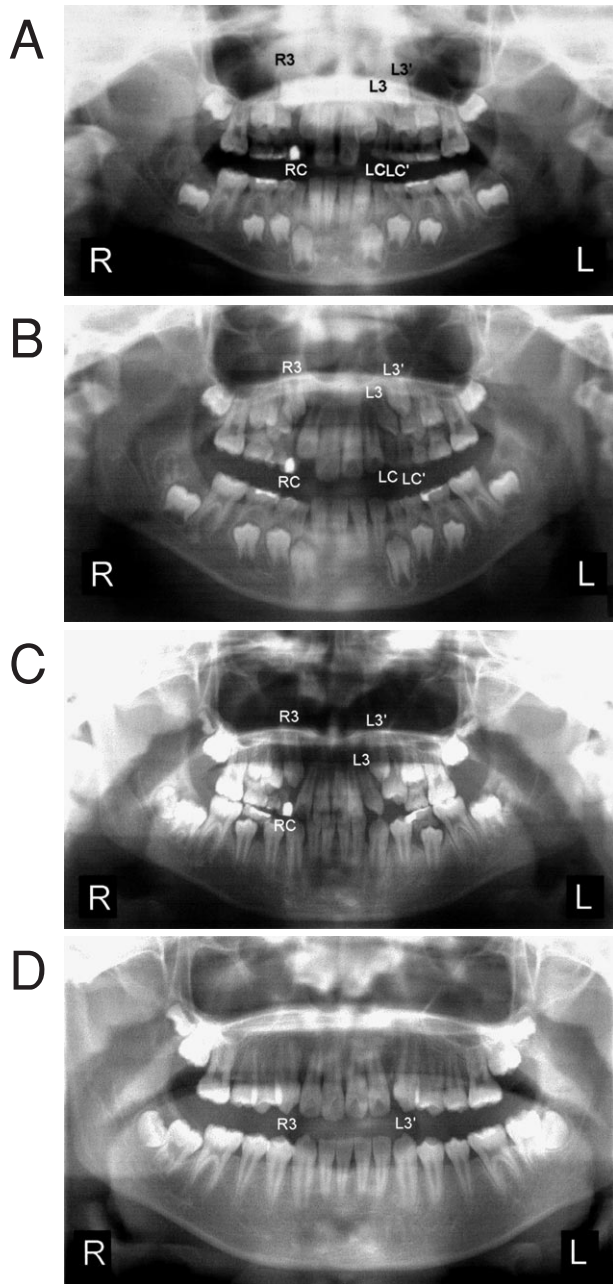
Orthopantomographs taken at 8Y5M (A), 9Y4M (B), 10Y9M (C), and 12Y2M (D)
